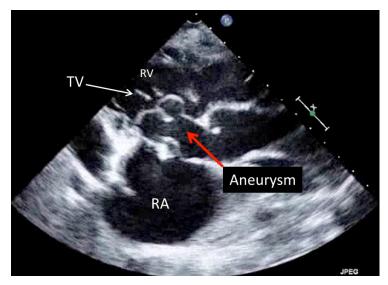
Transthoracic echocardiogram: 2D modified parasternal long-axis view angled toward the tricuspid valve showing aneurysm of the non-coronary sinus of Valsalva obstructing right ventricular inflow. RAright atrium, RV-right ventricle, TV-tricuspid valve.
